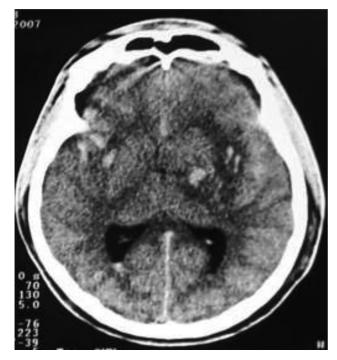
Non-contrast skull computed tomography showing bilateral lesion in basal ganglia.
